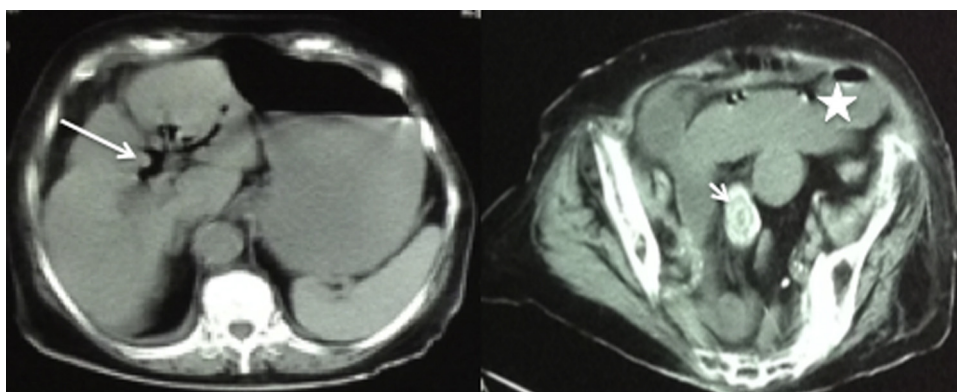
Abdominal CT displaying Rigler's triad, pneumobilia (white arrow), bowel loop.
